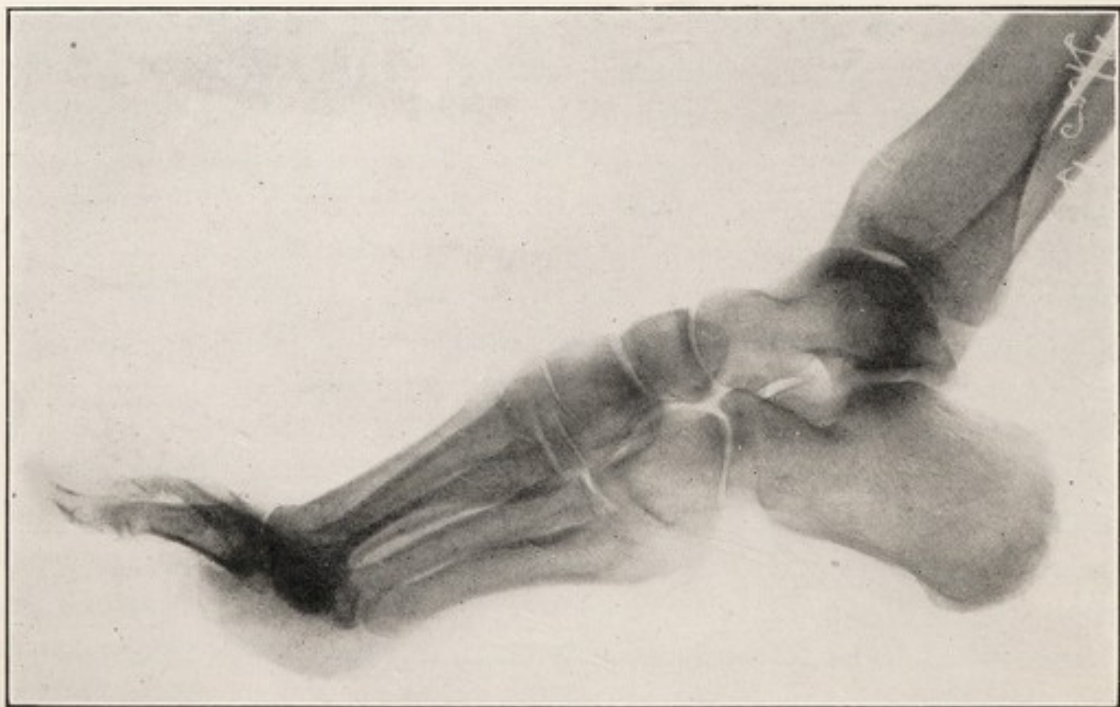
X-RAY OF NORMAL FOOT OF ADULT.
